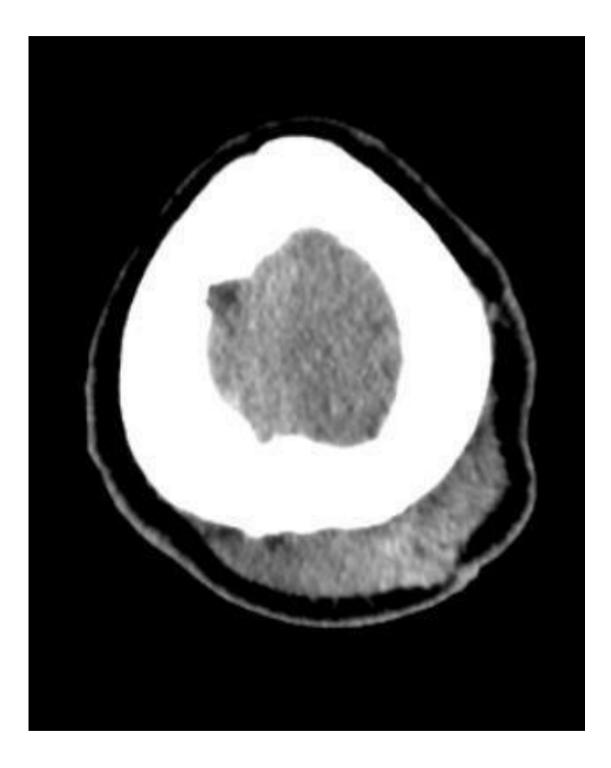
Axial CT scan brain demonstrates Soft tissue swelling in left parietal region
